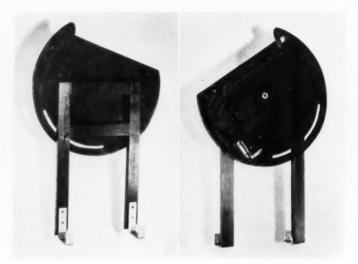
Front view of Dr. Law's x-ray holder for Roentgenograms of the cervical region.
